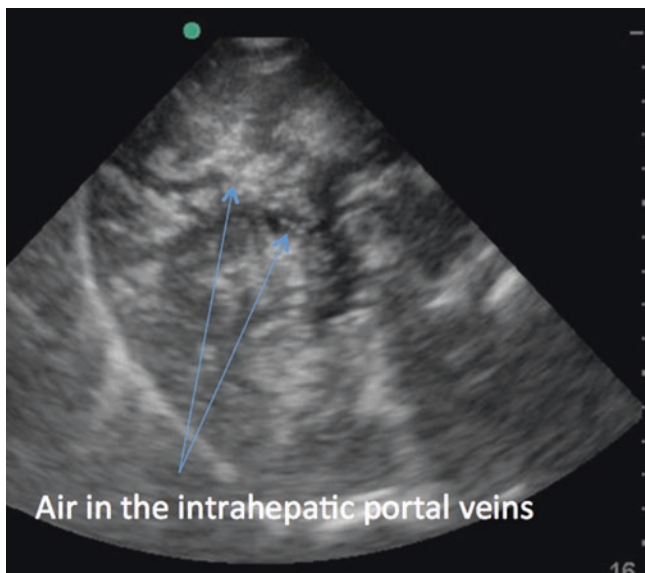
Bedside ultrasound for liver disease. Point-of-care ultrasound examination reveals extensive air (hyperechoic white areas) in the portal venous circulation. This patient was admitted with profuse diarrhea and septic shock. He was subsequently diagnosed with severe *Clostridium difficile* colitis and pneumatosis intestinalis. See also Video 37.17, which shows the air bubbles in the portal circulation
